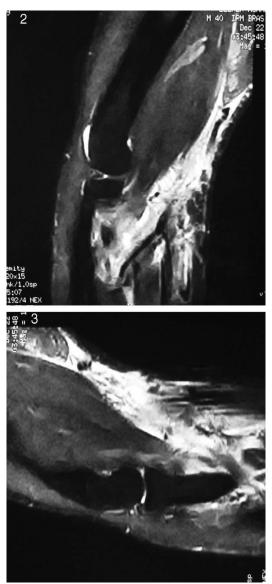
MRI of the elbow: disinsertion of the bicipital tendon at the level of the bicipital tuberosity
